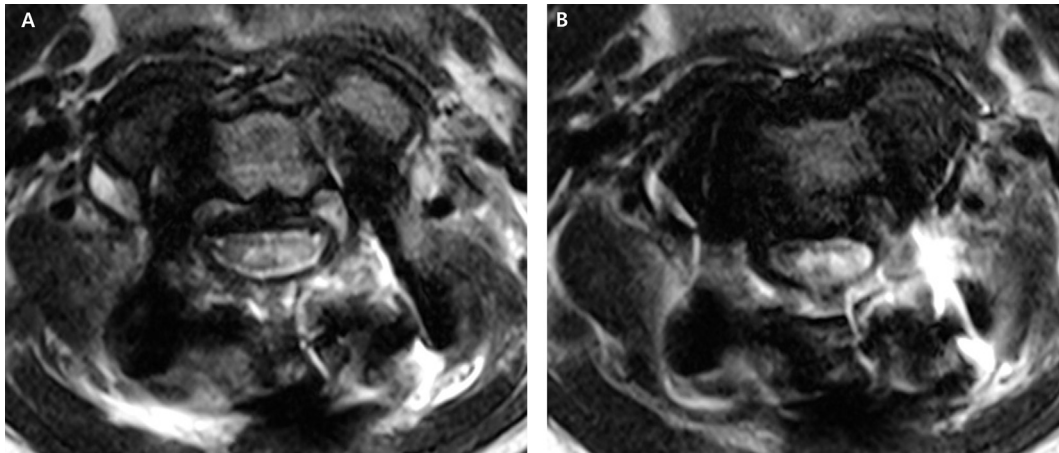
MR performed 3 days after surgery: axial MR image showing definite high signal change in the left hemisection of the spinal cord (A: C1 level, B: C1-2 disc level).
